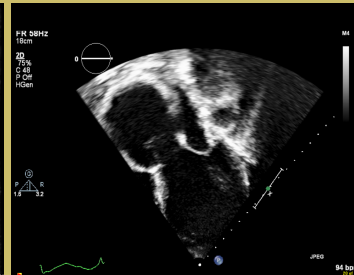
Still frame of the dilated ascending aorta and aortic root compared to the heart on transthoracic echocardiogram in an apical five chamber view.
